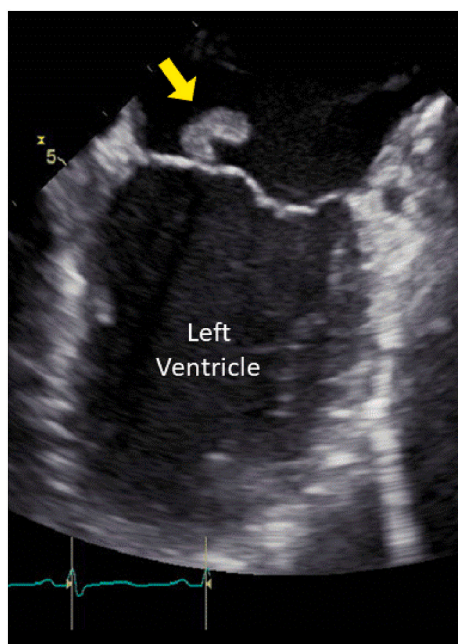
2D ultrasonic image of left heart and mitral valve vegetation (arrow).
